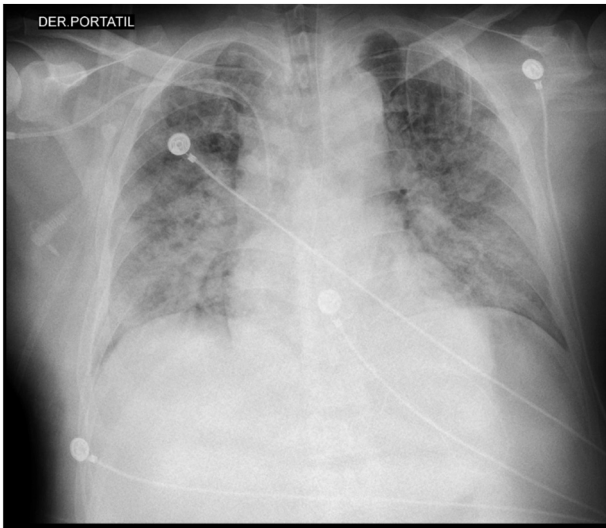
An anteroposterior (AP) chest radiograph showing diffuse alveolar interstitial infiltrates in both lung fields. The infiltrates are predominantly in the lower third zones of both lungs.
